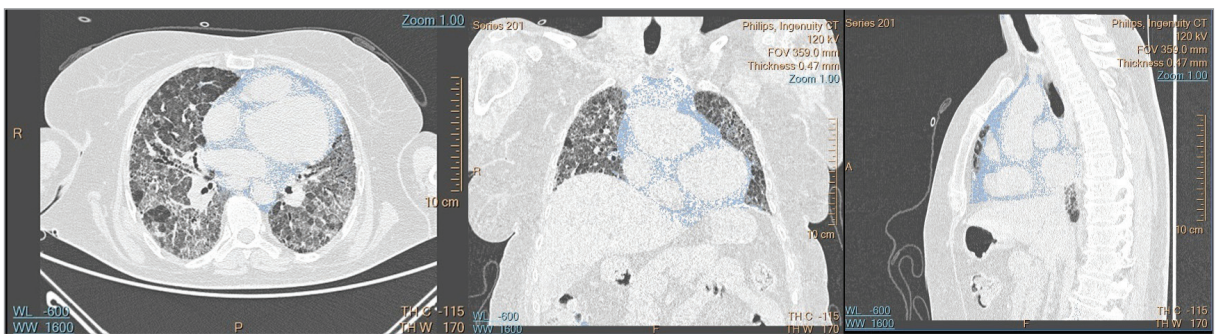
Measurement of mediastinal adipose tissue volume as observed in axial, coronal, and sagittal planes of HRCT.
